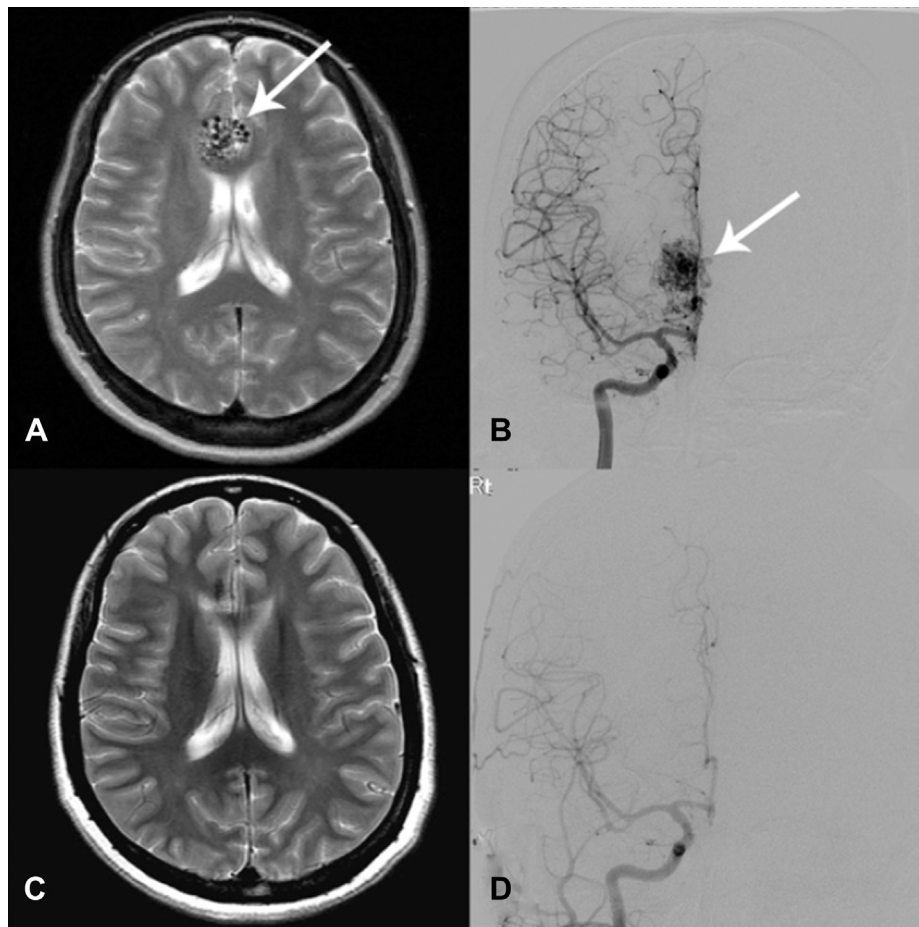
(A) Magnetic resonance imaging showed an arteriovenous malformation (AVM) encroaching on the right cingulate gyrus and corpus callosum. (B) The AVM was supplied by the branches of the right anterior cerebral artery and drained into the superior and inferior sagittal sinuses. Follow-up magnetic resonance imaging (C) and angiography (D) at 2 years after radiosurgery showed complete disappearance of the AVM.
